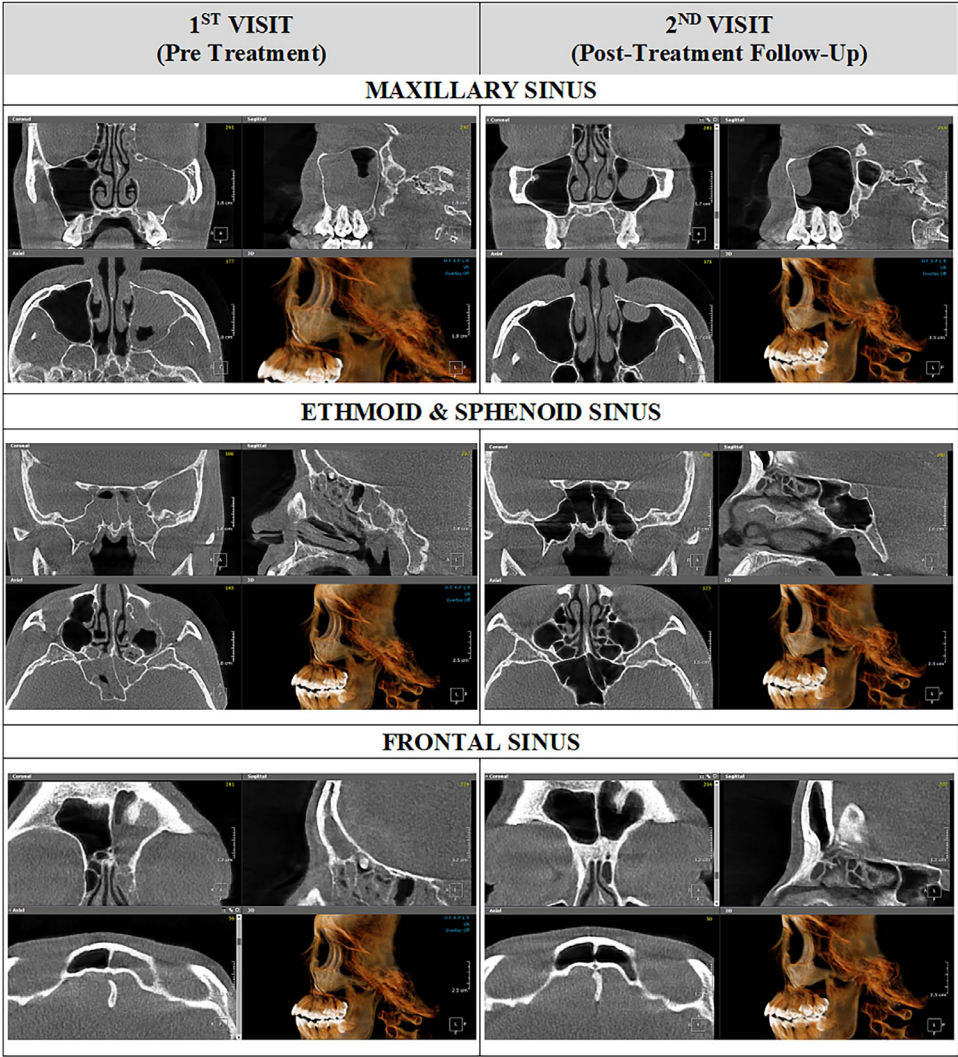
Comparison of CBCT examination of all paranasal sinuses of the patient at the first visit (pretreatment) and second visit (post-treatment follow-up). Note the uniform opacification and mucosal lining thickening of all sinuses at the first visit. The clouding had mostly vanished 1 month after receiving the medication, but a secondary dome-shaped radiopaque lesion was discovered on the anterosuperior wall of the existing maxillary sinus.
